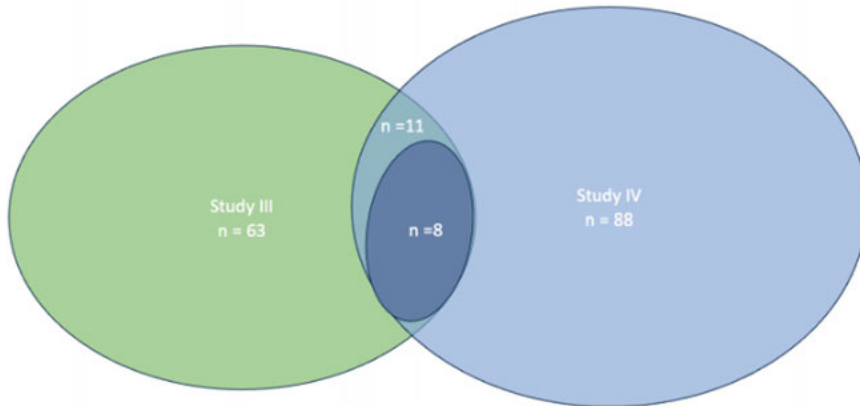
Cohort overlap between Study III and Study IV. Study III included 63 patients and Study IV included 88 patients. Eleven patients were included in both studies (overlapping region). For eight of these patients, the same 18F-fluoride PET/CT examination was used in both studies; SUVmax values were recalculated separately for each study according to the respective analysis protocol.
